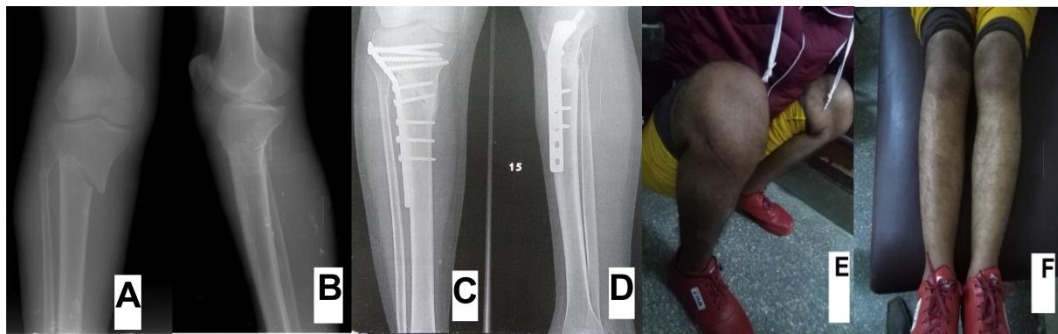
1 case1: Pre-operative x-ray anteroposterior(A) and lateral(B) views; (4) months follow up x-ray anteroposterior(C) and lateral(D) views showing full union of the fracture; full ROM (130° flexion(E) / 0° extension(F))
